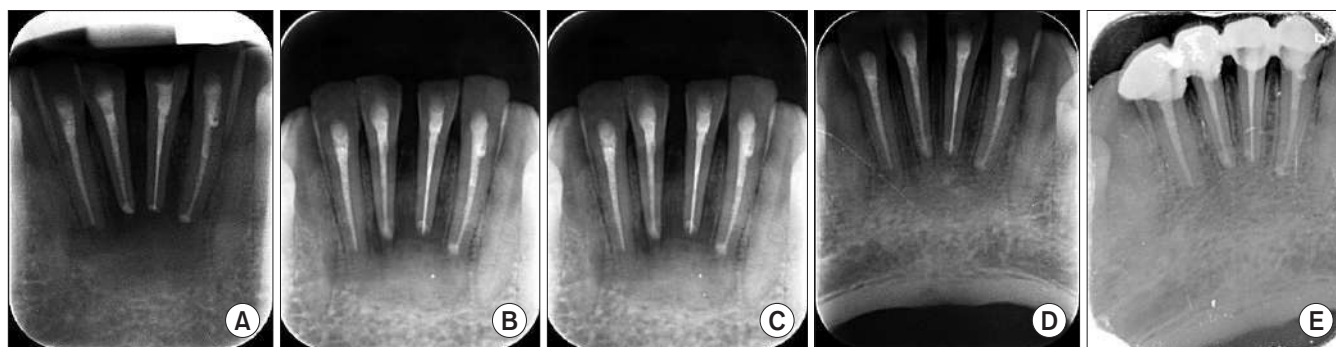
Intraoral periapical radiographs showing radiological evaluations of lesion. A. Immediately after grafting. B. Four weeks postoperative. C. Eight weeks postoperative. D. Twelve weeks postoperative. E. Twenty-four weeks postoperative.
